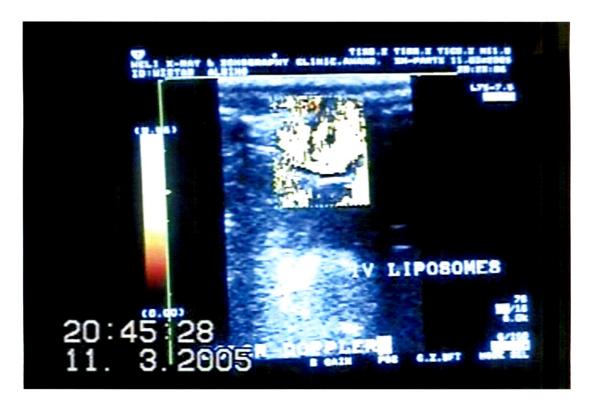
A caridac image showing doppler signals received (red color) in harmonic imaging (Power Doppler) after administration of liposomes
